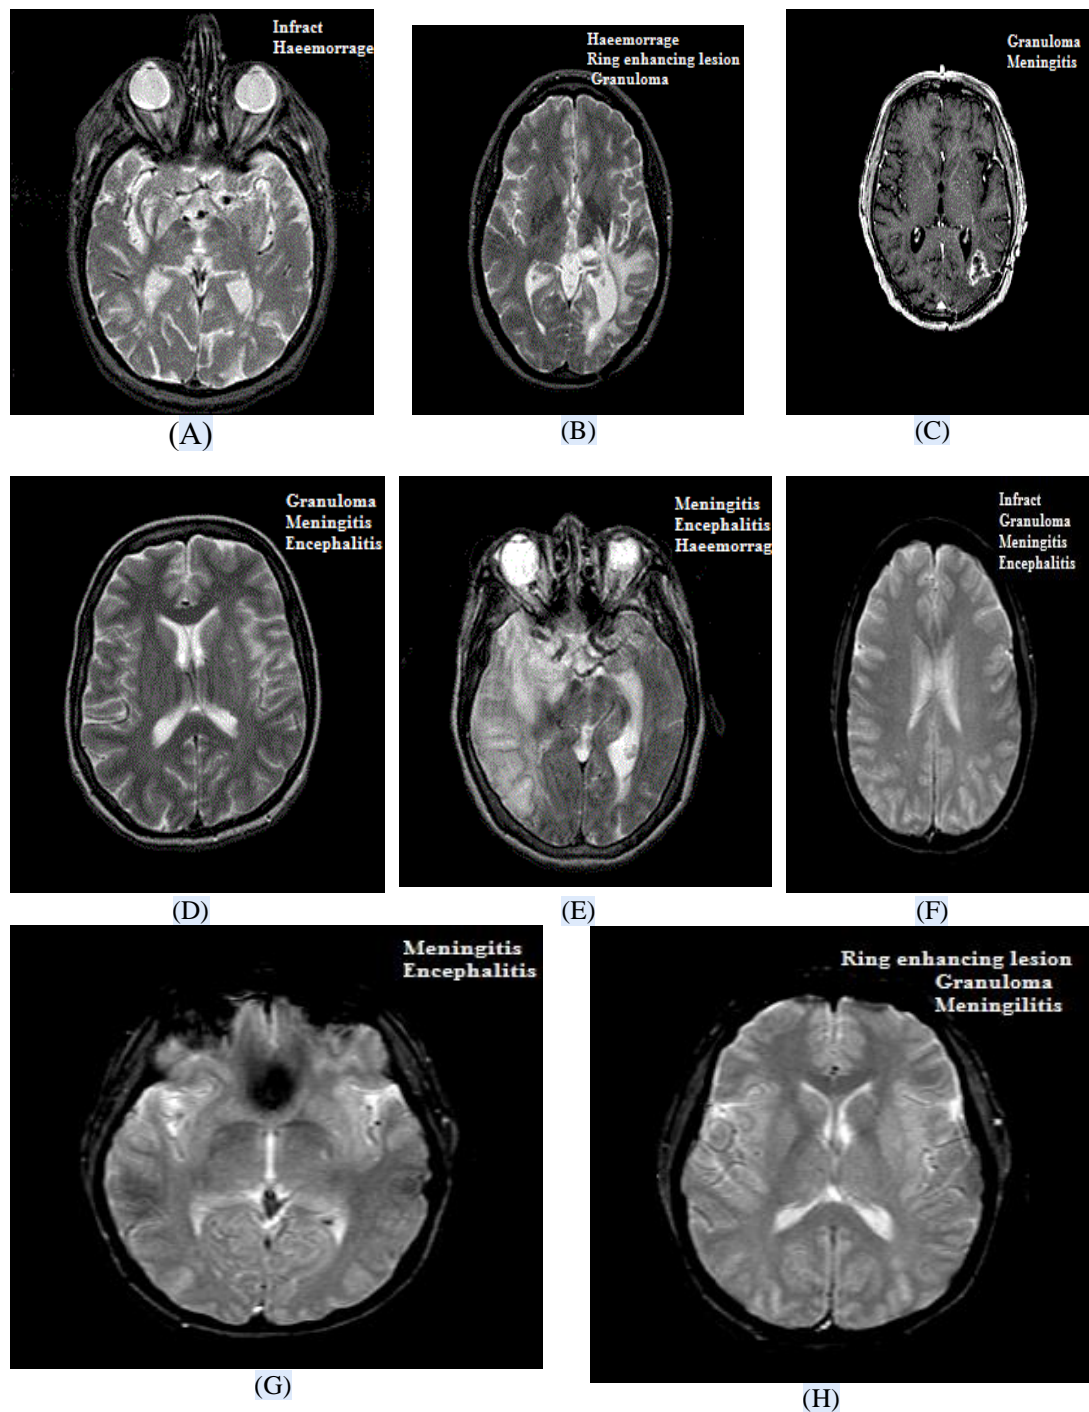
Experimental results of various abnormalities detected through the various samples of the MRI
